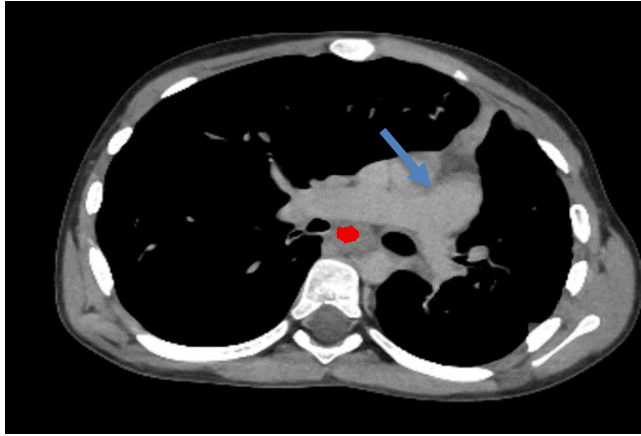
Axial Sections of Contrast Enhanced CT Chest, mediastinum window, showing normal pulmonary trunk and right and left pulmonary arteries, blue arrow. Enlarged subcarinal lymph node is also seen, labelled as red asterisk.
